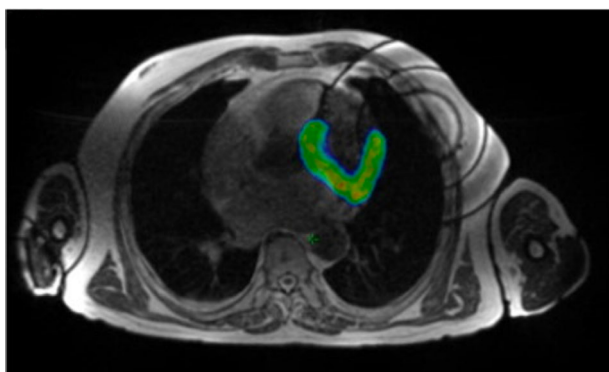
Example images from the first-in-human MRI-guided radioablation at 0.35 T with estimated delivered radiation dose overlaid. [Adapted from Mayinger et al.¹¹⁵]
